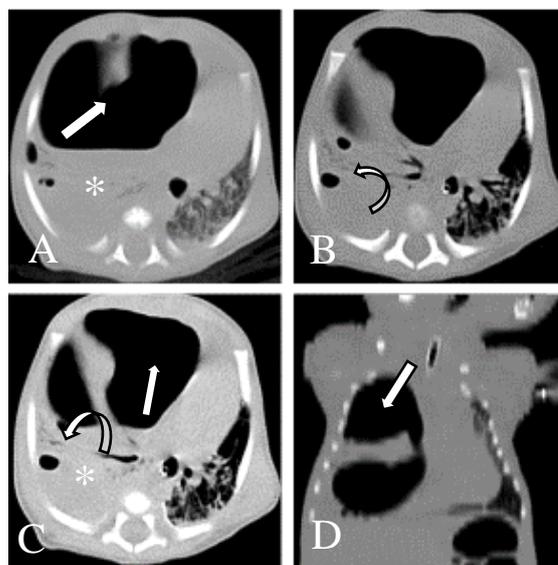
Noncontrast chest computed tomography scans in axial (A, B and C) and coronal (D) views demonstrate a large septated "coffee bean-shaped" air collection in the anterior aspect of the hemithorax (white arrow on A, C and D), extending from the lung apex to the diaphragm, with interposed compressed lung parenchyma (possibly part of the middle lobe – asterisk on A and C) between these air collections and numerous cystic, air-filled spaces in the rest of the compressed lung parenchyma (curved arrow on B and C). The ipsilateral increased intercostal spaces, depression of the diaphragm, and contralateral mediastinal shift were evident.
